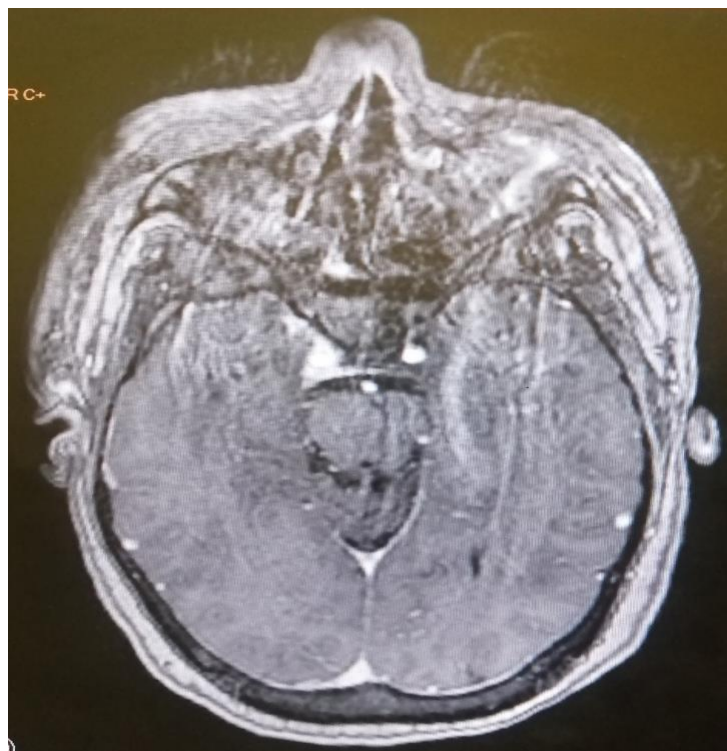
Brain angio-MRI showing a cavernous sinus thrombosis
